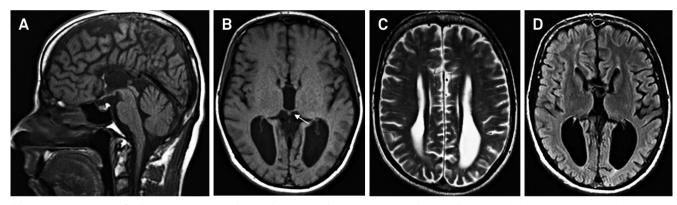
Neuroimaging findings in nonketotic hyperglycinemia. Sagittal and axial brain MR images disclosing nearly complete corpus callosum agenesis (sparing only a small portion of the genu) and interhemispheric connection by posterior commissure (white arrow) in T1-weighted (A, B), T2-weighted (C) and FLAIR (D) sequences. Putamina, anterior commissure and hemispheric supratentorial white matter are also thin.
